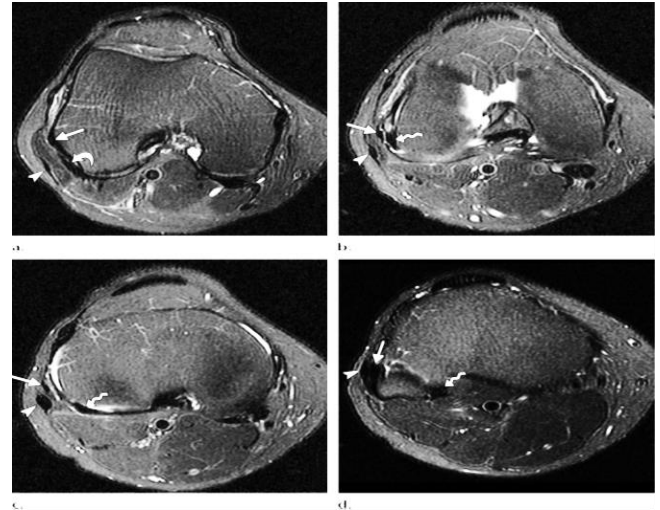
Consecutive axial T2-weighted fat-suppressed MR images show the normal course and MR imaging appearance of the LCL (straight arrow), biceps femoris tendon (arrowhead),and popliteus tendon(wavy arrow in b–d).The origin of the LCL is immediately anterior to the femoral attachment of the lateral head of the gastrocnemius tendon(curved arrow in a) (28).
